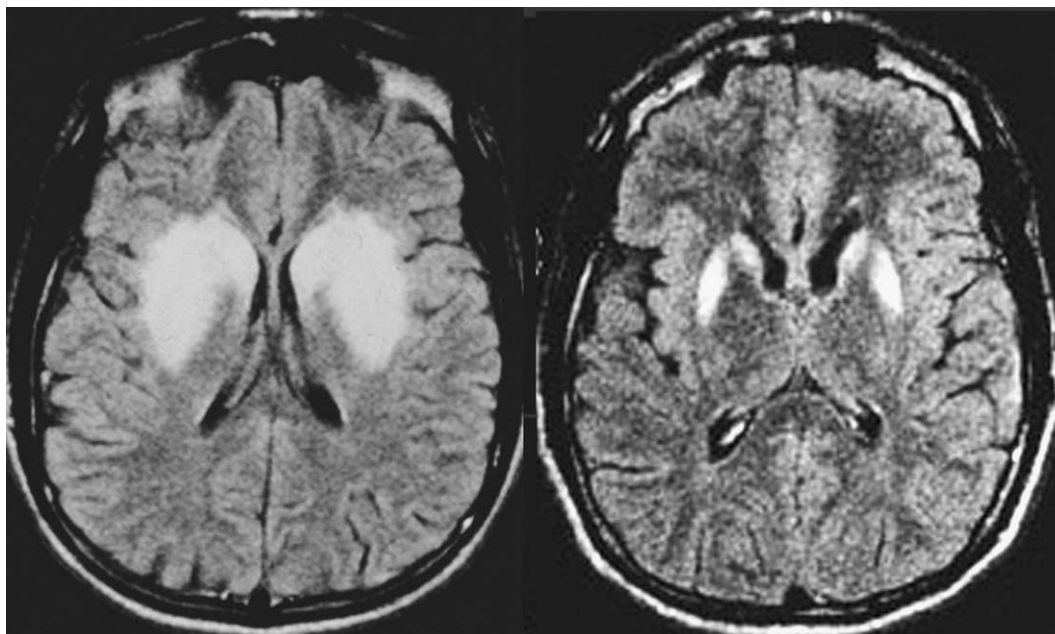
Axial FLAIR images (TR: 11000 TE: 140) shown on the left, during the acute phase, marked swelling and abnormally increased signal intensity of the putamen and caudate nuclei bilaterally. On the right, the MRI performed 9 months later, demonstrates bilateral striatal atrophy and persisting high signal intensity.
